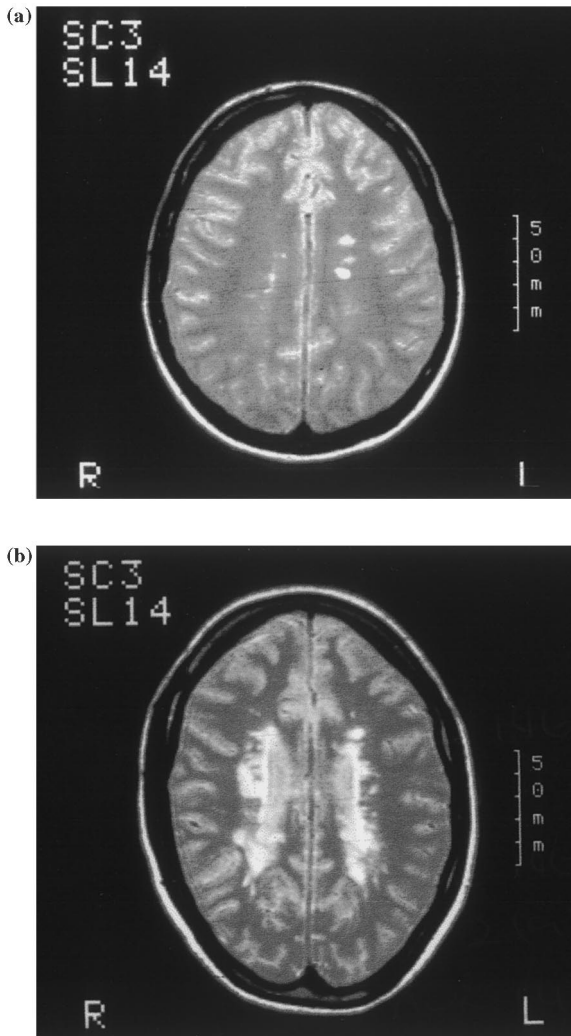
Magnetic resonance imaging scans of brains of two patients with multiple sclerosis showing the characteristic periventricular localizations of plaques during (a) early and (b) late phase of relapsing-remitting disease (By courtesy of Dr Jan Lycke).
